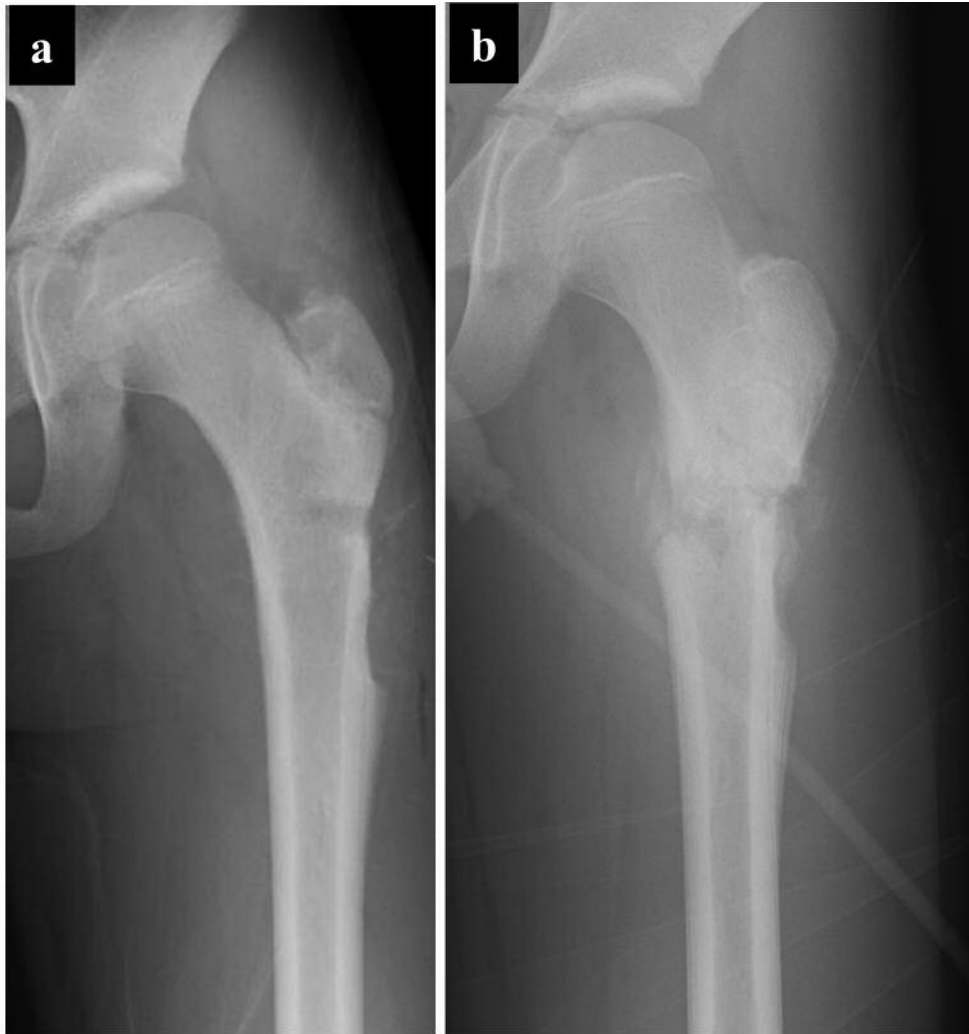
Radiograph of a 12-year-old male patient with Ewing Sarcoma who underwent bone biopsy of the left femur (a). Unfortunately, femur fracture occurred on the site of the biopsy hole (b).
